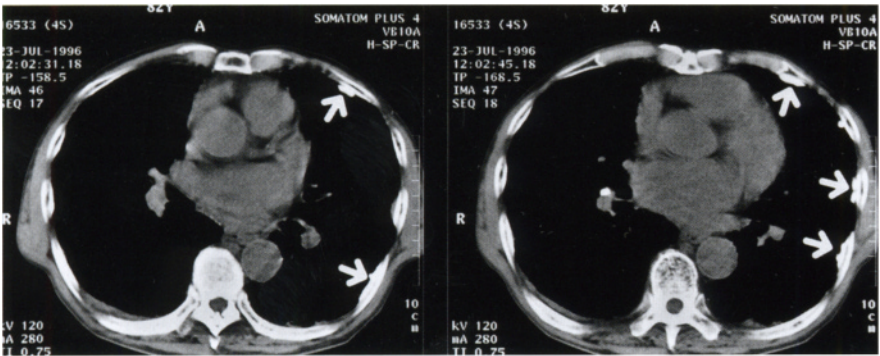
CT images with mediastinal window setting show calcified plaques in the left middle lung zones, suggesting asbestos-related pleural abnormalities (*white arrows*)
